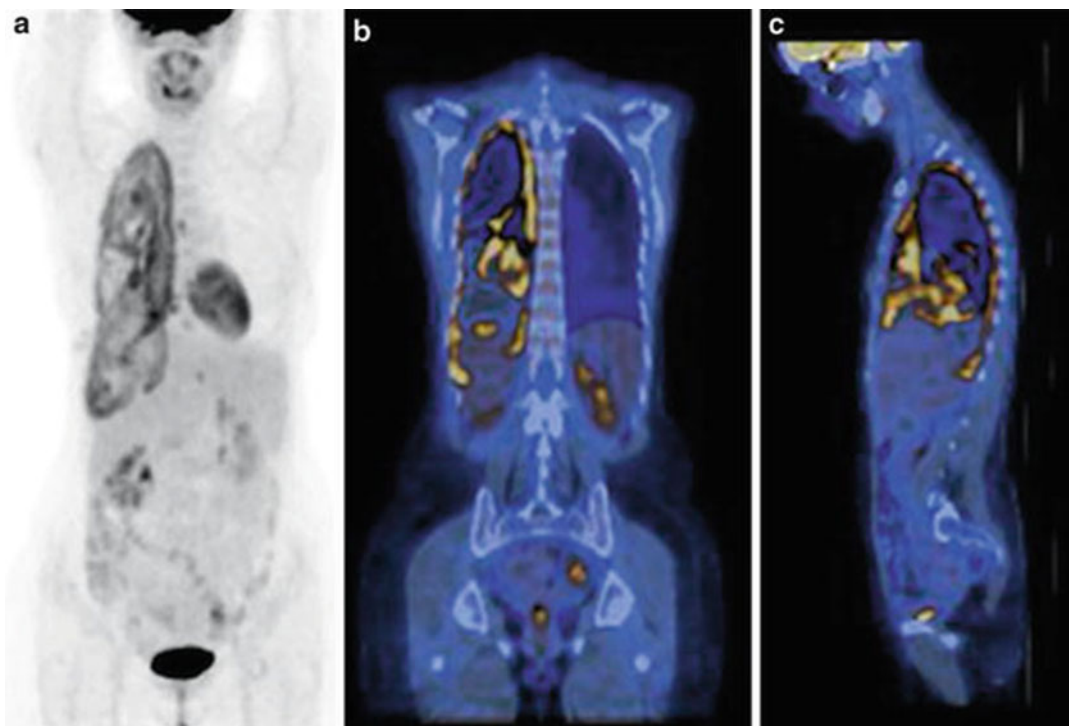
Whole body [^{18}F]FDG PET/CT in patient with suspected recurrent breast cancer ((a), maximum intensity projection, (b) coronal fused PET/CT, (c) sagittal fused
